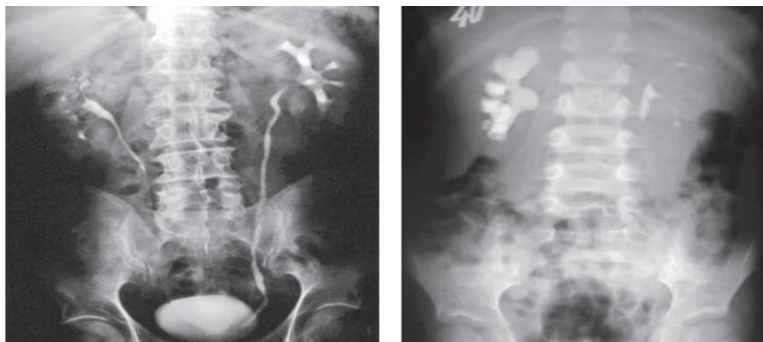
Excretory urogram: a - roentgen negative stone bowls left kidney, b - a staghorn stone in right kidney, marked dilatation of the pyelocaliceal system of the right kidney
